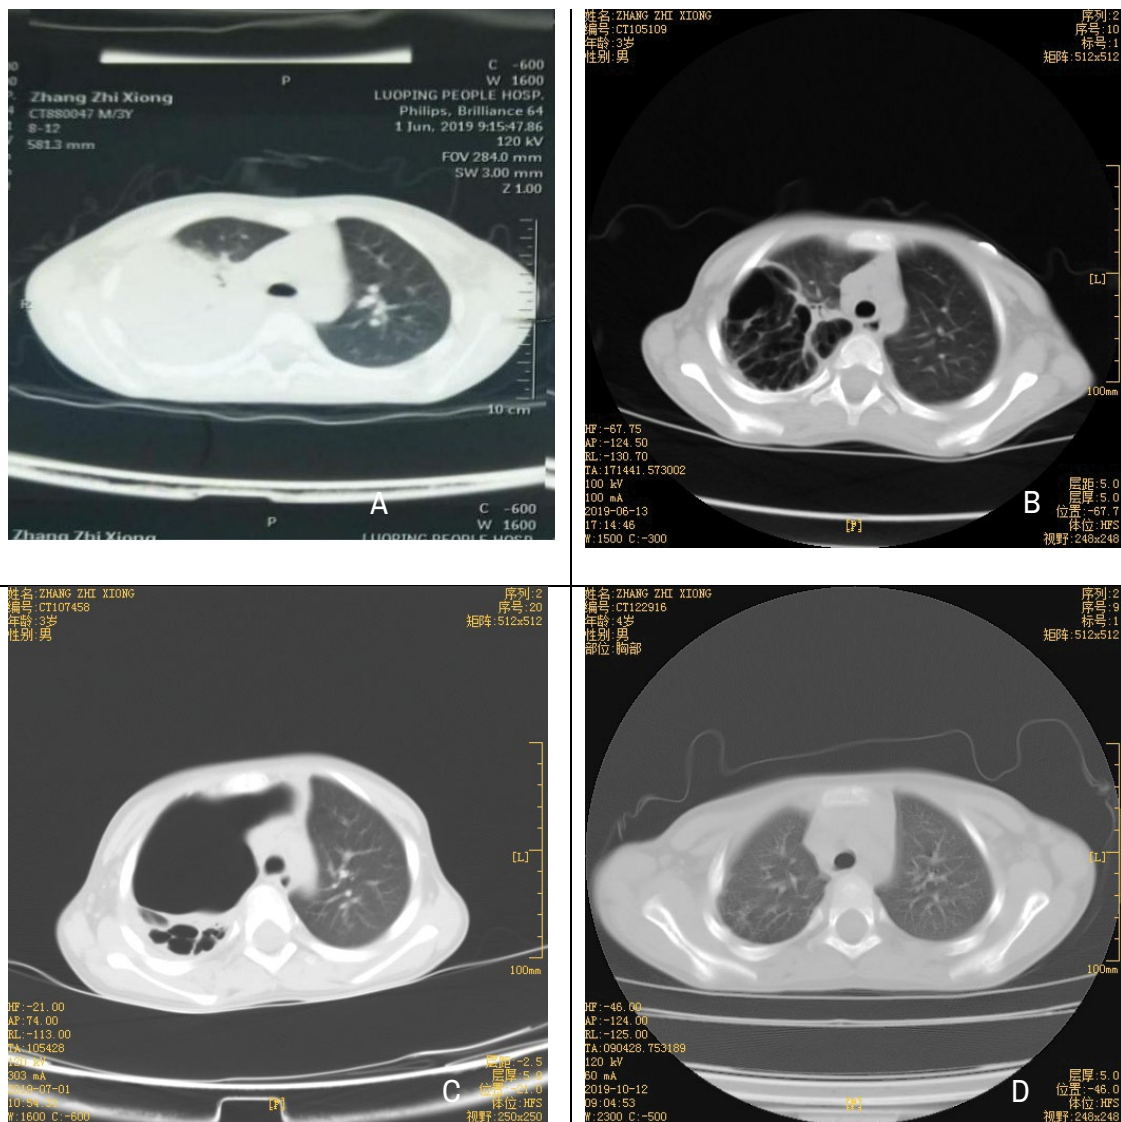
Evolution of chest CT without contrast in case one. (A) Large consolidation in the upper lobe of the right lung at the onset of disease. (B) Second thoracic CT after 12-day treatment showing an extended pneumatocele with multiple septum inside at almost the same section. (C) The third cheAst CT at two weeks interval showing a fused tensile pneumatocele protracting to mediastinum with thickened interlobular septum and patch shadow in the upper lobe of the right lung. (D) The fourth CT three months later showed primary pneumatocele had been totally replaced by normal lung tissue. (Note: Figure 1A was taken at another hospital and captured by cell phone).
